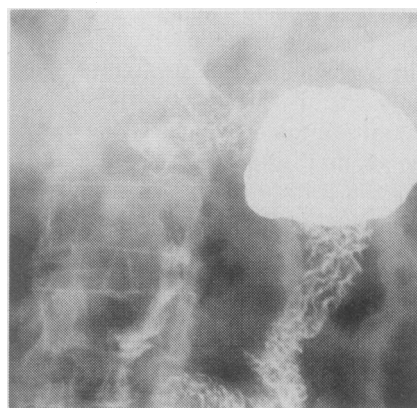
Barium x-ray film 10.5 years after subtotal gastrectomy for antral carcinoma, showing normal gastric remnant and normal small bowel.
